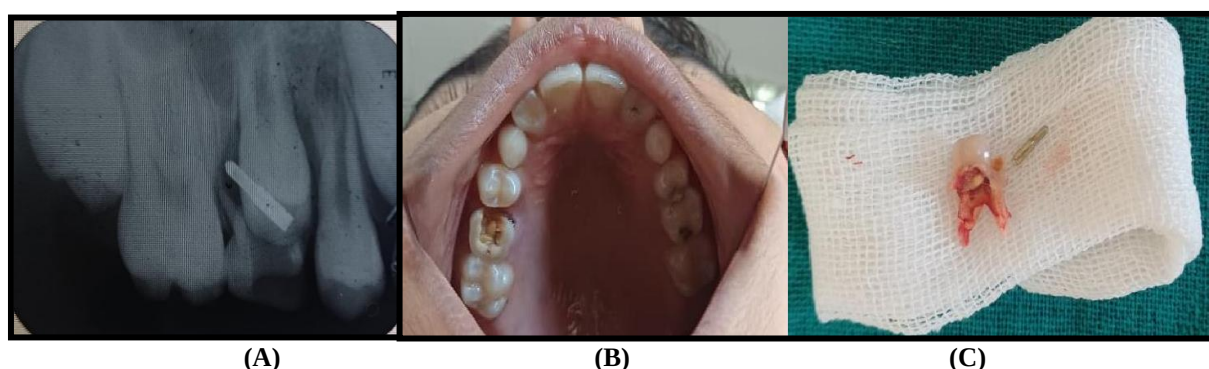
(A) An IOPA radiograph showing presence of the foreign object wrt grossly carious tooth 55 with evidence of physiological root resorption. (B) A foreign object, identified as a pen tip seen in the carious cavity of tooth 55. (C) Extraction of the tooth along with the retrieval of the pen tip.
